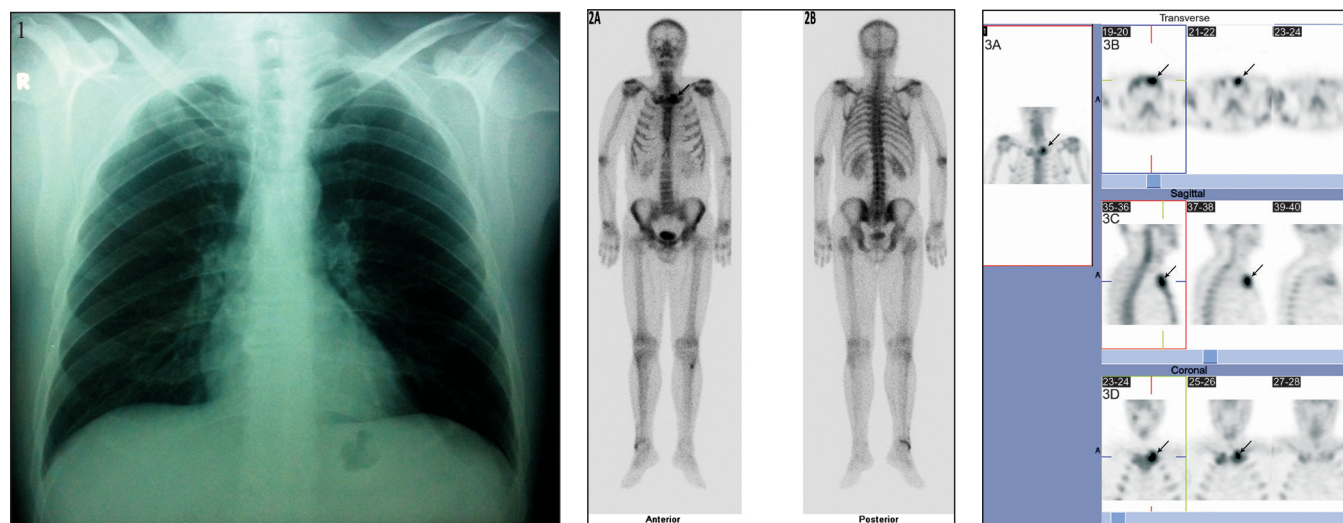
Chest X-ray of the patient shows normal findings. Fig. 2A-B. Anterior and posterior whole body scintigraphic image showing left SCJ involvement (arrow). Fig. 3A-D. Bone scintigraphic image showing left SCJ involvement (arrows) due to brucellosis.
